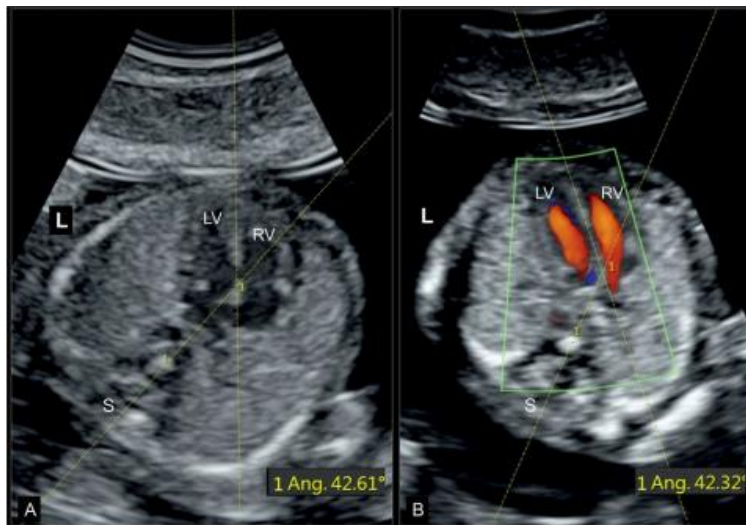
” fetus at 13 weeks’ gestation with normal cardiac axis in B mode (A) and color Doppler (B).In a four-chamber view of the heart the cardiac axis by the angle of two lines; the first one begin at the spine (S) posteriorly and ends in midchest anteriorly, which divided the chest into two equal halves, the second one runs through the ventricular septum. This angle is 42 degrees (normal). RV, right ventricle; LV, left ventricle; L, left” [1].
